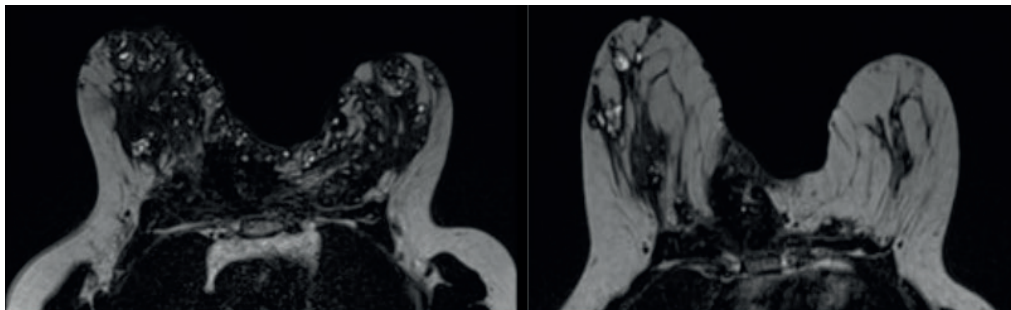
Breast MRI: multiple diffuse snowstorm images occupying all quadrants of both breasts.
